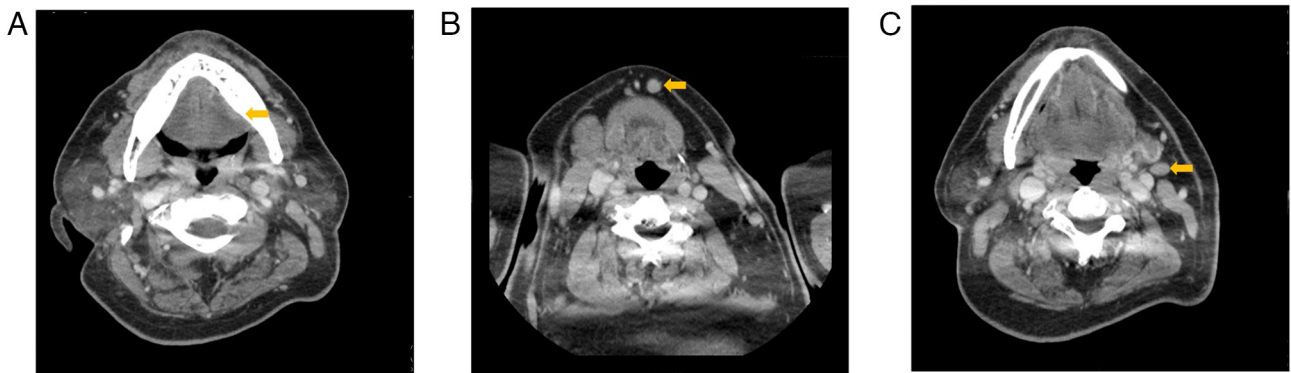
Contrast-enhanced computed tomography images. (A) A neoplastic lesion measuring 25x15x4 mm was observed on the left side of the tongue. Mild enlargement was observed in the (B) submental and (C) left submandibular lymph nodes.
